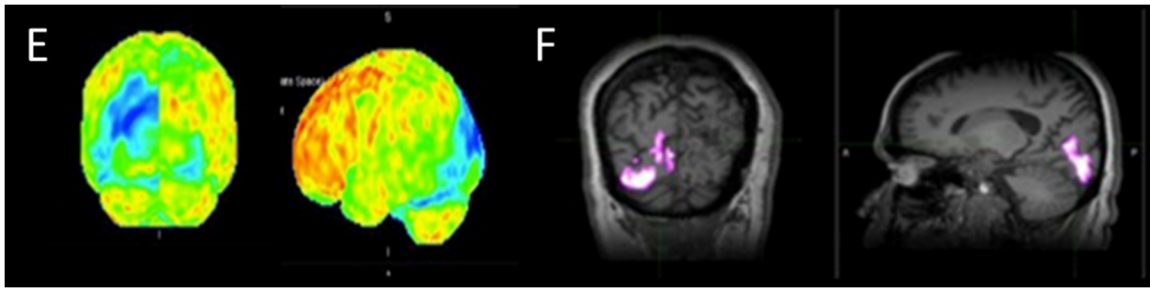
^{18}F -FDG PET for Epilepsy E) SSP (stereotactic surface projection) Ictal scan
